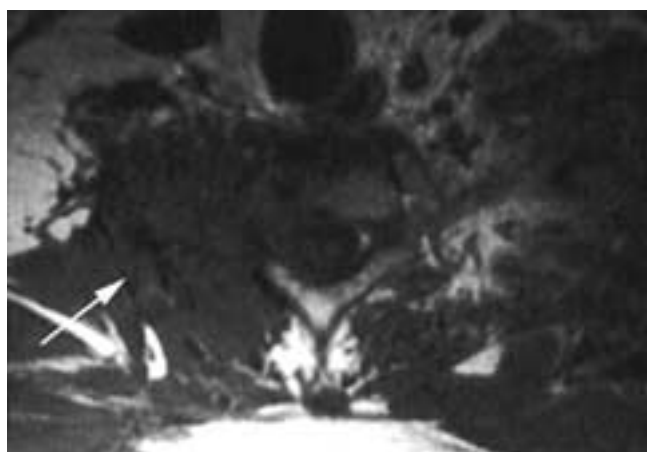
Metastatic lung carcinoma. T1-weighted MR axial image demonstrates a large soft-tissue mass (arrow) that engulfs the right scalene muscles.
